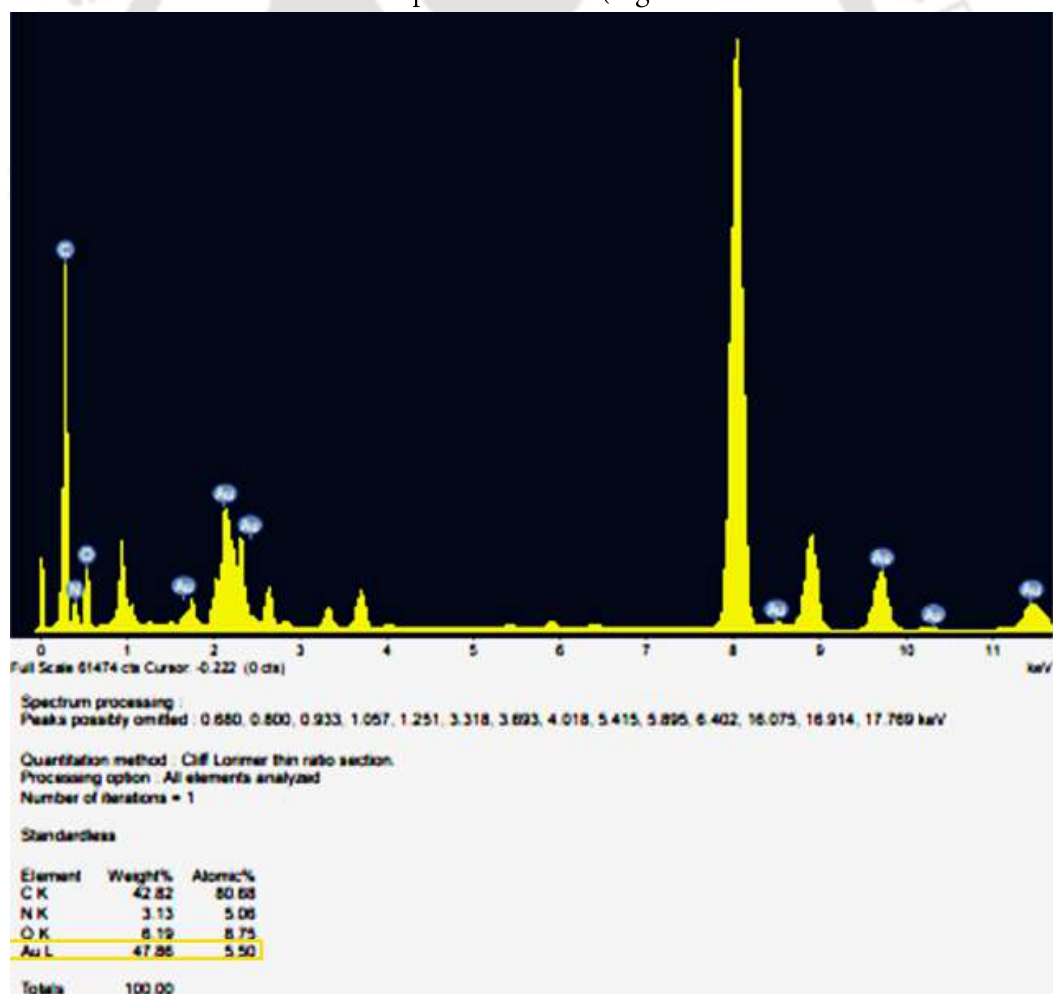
Energy dispersive X-ray analysis. Results of EDX analysis of Lac_AuNC.
